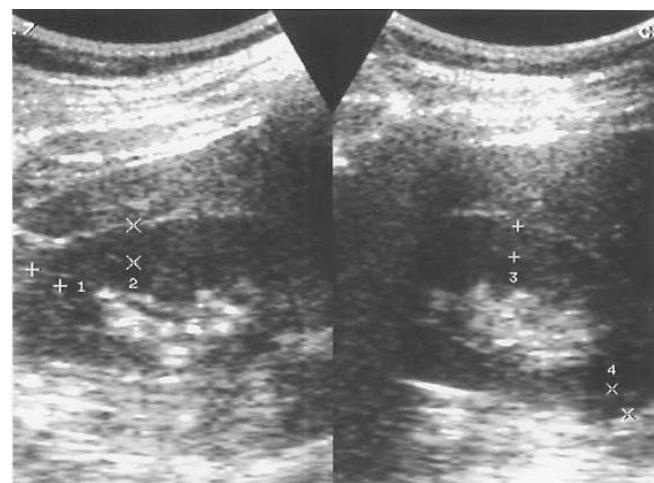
The sonographic view of the measurement of renal cortical thickness in four points of the kidney.
